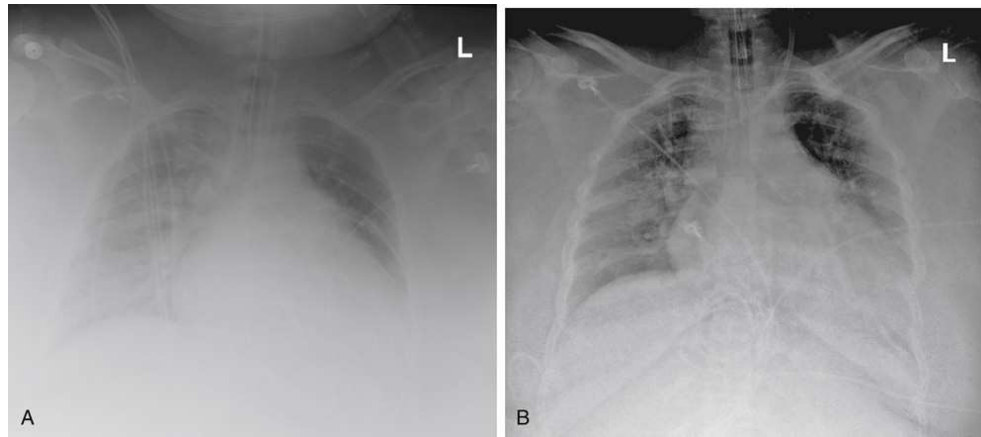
Mobile chest radiographs of an obese patient. (A) AP projection with no grid. (B) AP projection of the same patient using a grid. Note increased contrast resolution in image B.
